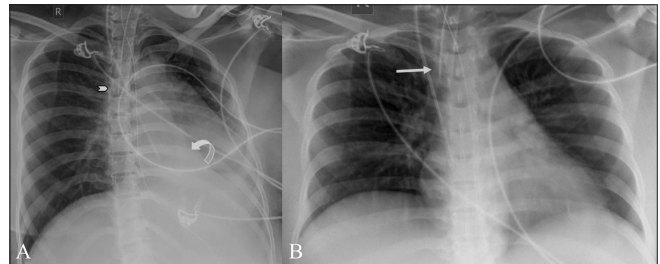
(A, B): Frontal chest radiographs show an endotracheal tube in the right main bronchus (arrowhead in A), causing hyperinflation of the ipsilateral lung and partial collapse of the left lung (curved arrow in A). After withdrawal of the tube into the trachea (arrow in B), the left lung has inflated
